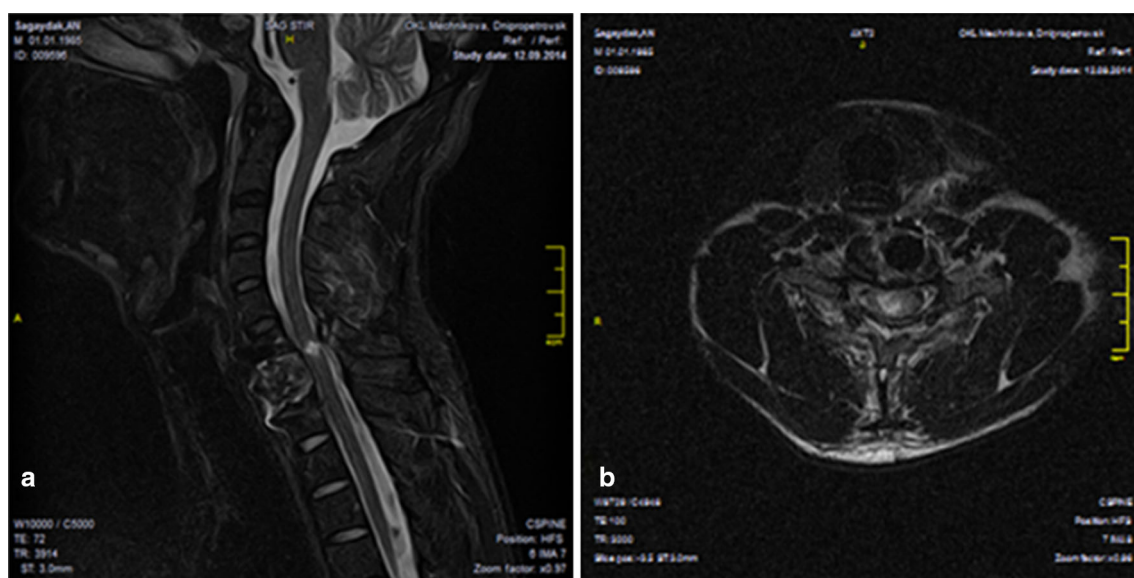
Magnetic resonance images. Compression and comminuted fracture of C7, with myelopathy at the same level. a Sagittal view. b Axial view
